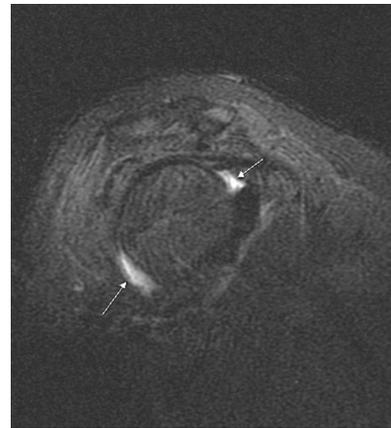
The MRI of right shoulder (STIR).
